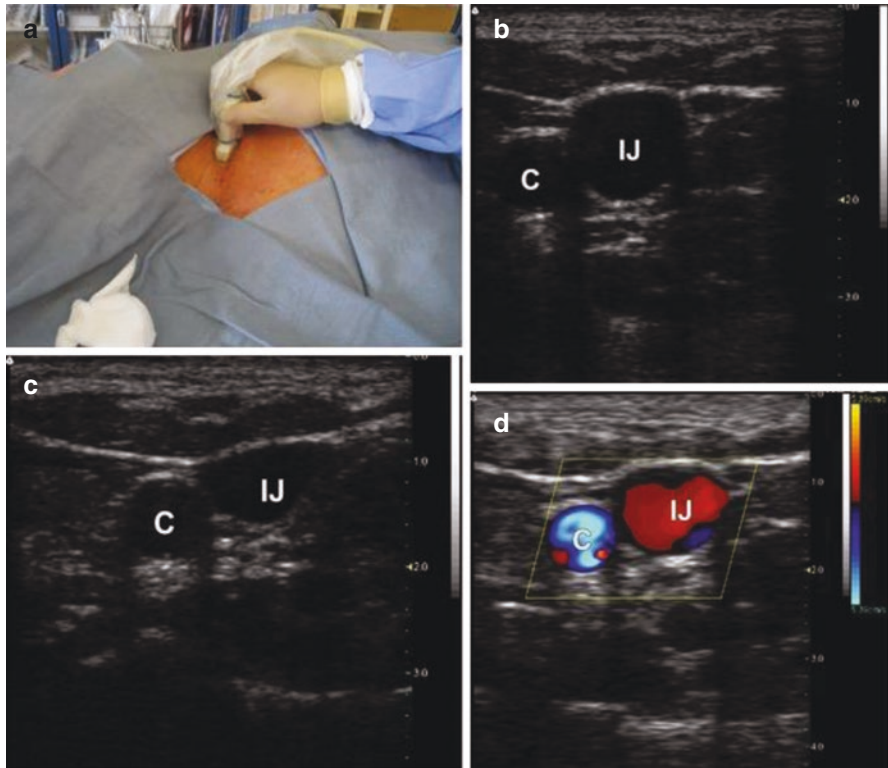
(a) Place the ultrasound probe just above the clavicle, between the two heads of the sternocleidomastoid muscle. (b) The internal jugular (IJ) vein lies lateral to the carotid artery. (c) The internal jugular vein is easily compressible with the ultrasound probe. (d) Occasionally, color Doppler may be used to confirm flow within the vessels. C carotid artery; IJ internal jugular vein
